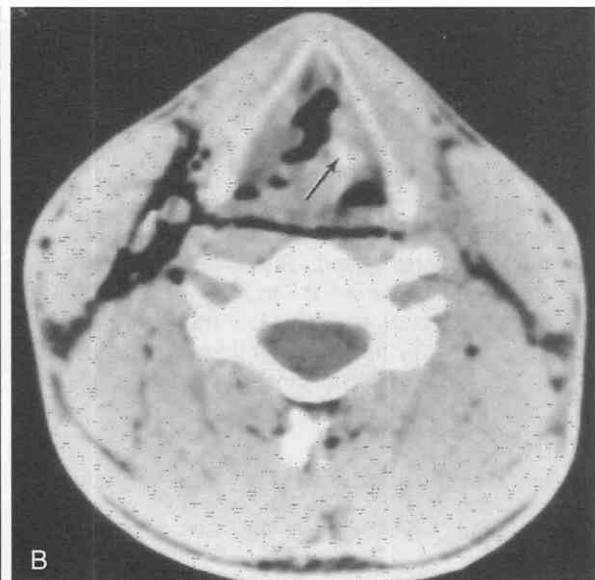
Arytenoid dislocation. A, CT axial slice through the level of the cricoarytenoid joint. There is a normal configuration on the right. The arytenoid cartilage (arrow) articulates normally with the small articular surface of the cricoid (arrowhead) on the superior edge of the cricoid cartilage. The arytenoid on the left is not identified in a normal position. B, Higher slice shows the dislocated arytenoid (arrow) in the supraglottic area.
